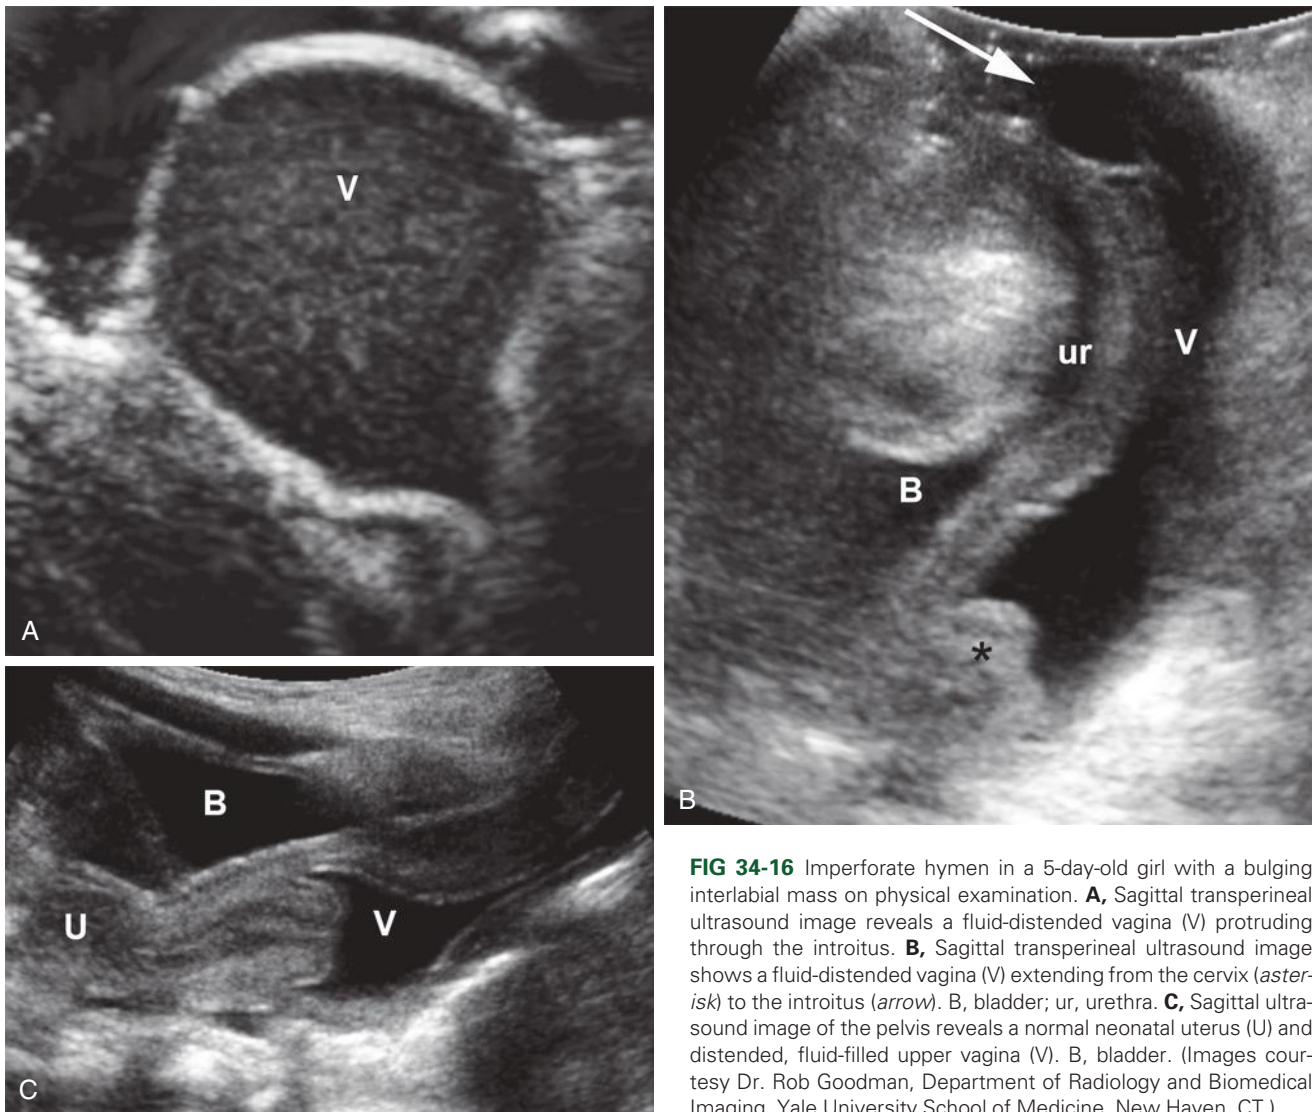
Imperforate hymen in a 5-day-old girl with a bulging interlabial mass on physical examination. A, Sagittal transperineal ultrasound image reveals a fluid-distended vagina (V) protruding through the introitus. B, Sagittal transperineal ultrasound image shows a fluid-distended vagina (V) extending from the cervix (*asterisk*) to the introitus (*arrow*). B, bladder; ur, urethra. C, Sagittal ultrasound image of the pelvis reveals a normal neonatal uterus (U) and distended, fluid-filled upper vagina (V). B, bladder. (Images courtesy Dr. Rob Goodman, Department of Radiology and Biomedical Imaging, Yale University School of Medicine, New Haven, CT.)
